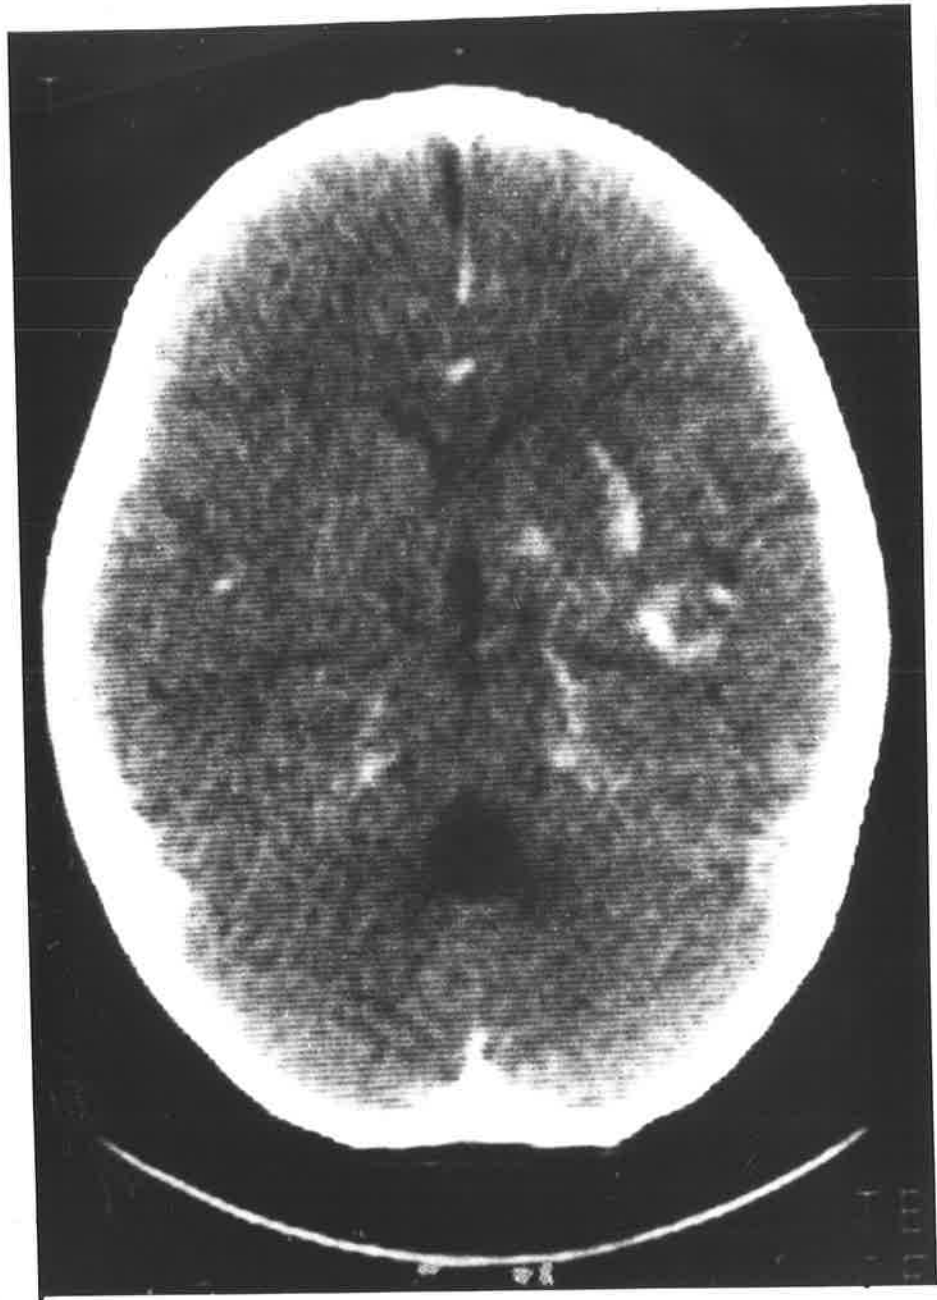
Unenhanced axial CT scan performed 16 hours after head injury in a 9 year old boy who was knocked off his bicycle by a motor car (case 3). He suffered a major head injury that was complicated by apnoea and cyanosis. The major features of the scan are bilateral, but predominantly left sided, thalamo-capsular hemorrhages.
